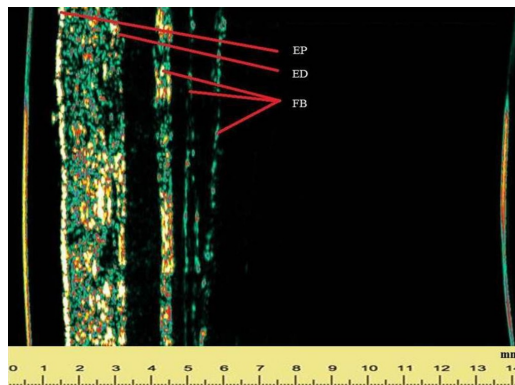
2D B-scan image from the arm by 20-MHz Ultrasound Skin Scanner. The epidermis (EP) entry and exit echoes become super-positioned in the case of thin epidermis layer. End of dermis (ED) is defined where the colourful echo stops and the black area starts. The fascia bundles (FB) of collagen fibre are presented as hyper-echoic bands
